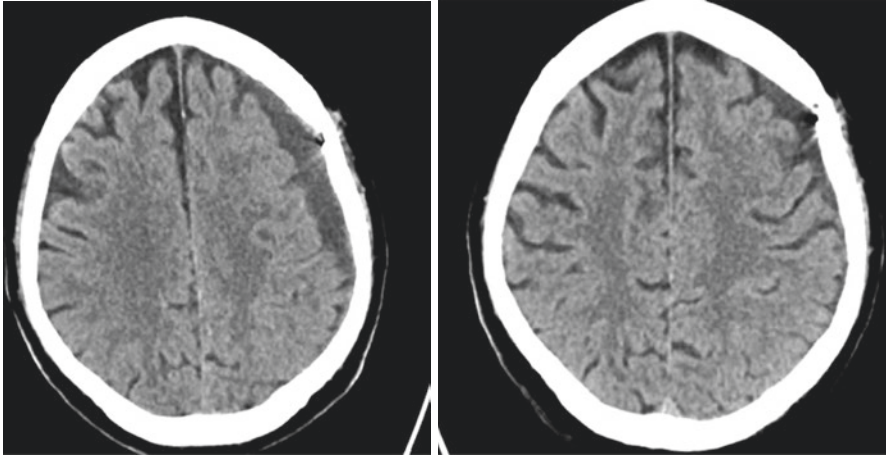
CT scans obtained at 1 month (left) and 2 months (right) post MMA embolization demonstrate progressive resolution of the hematoma over time
